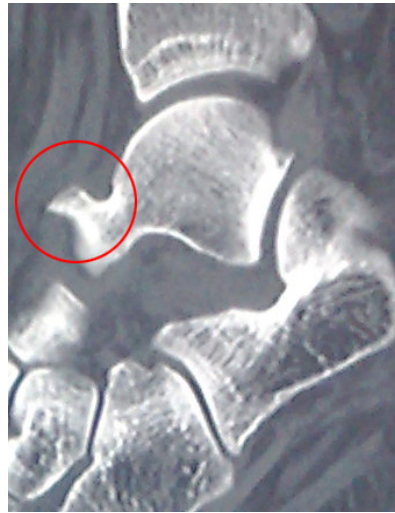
(left) and 3 (right). CT scan view of the talonavicular joint revealing the osseous lesion on top of the distal talar neck.
